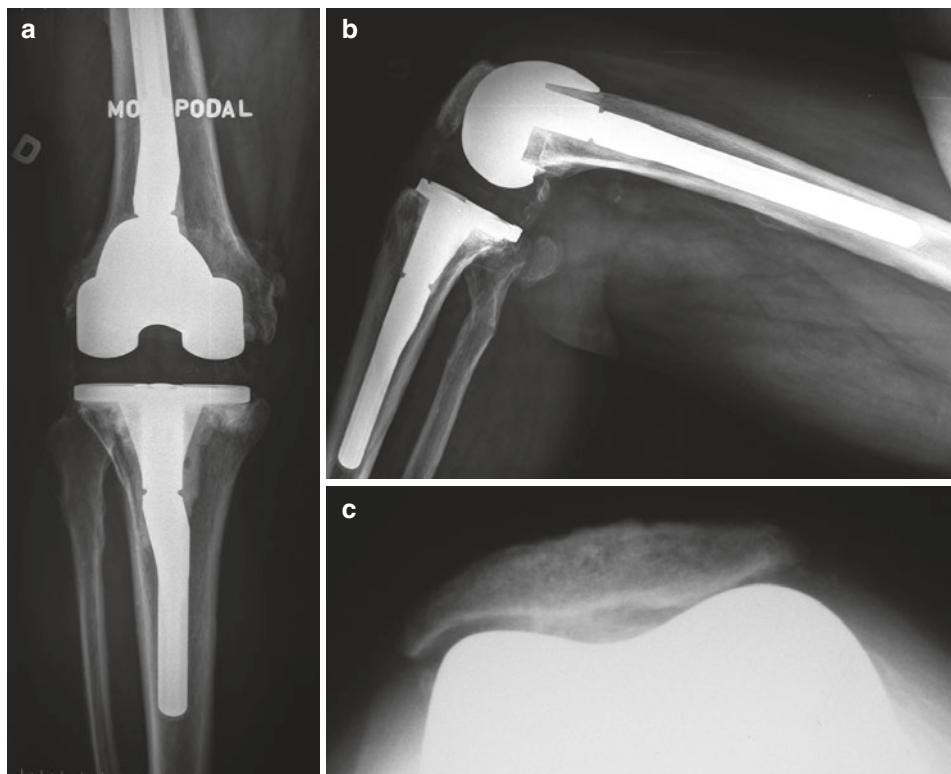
(a) Anteroposterior, (b) lateral, and (c) Merchant radiograph 2.4 years after second revision. Patella height and integrity maintained on lateral view
